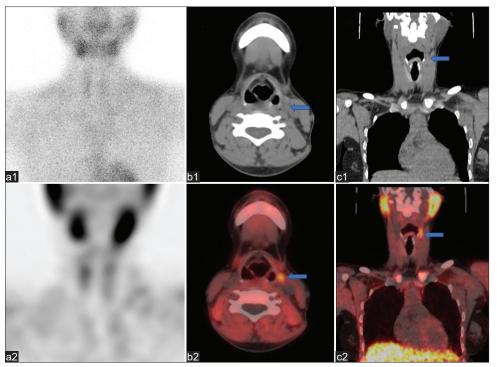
<sup>99m</sup>Tc-SestaMIBI scintigraphy planar (a1) and SPECT (a2) images reveal a negative scan and <sup>18</sup>F-fluorocholine PET/CT axial (b1 and 2) and coronal (c1 and 2) images reveal a soft-tissue density lesion (blue arrow marked), starting posterior to the left submandibular gland and extending from lateral to the left pyriform fossa up to level of left lamina of thyroid cartilage just medial to left sternocleidomastoid muscle with increased tracer uptake. PET/CT: Positron emission tomography/computed tomography, SPECT: Single-photon emission computed tomography
